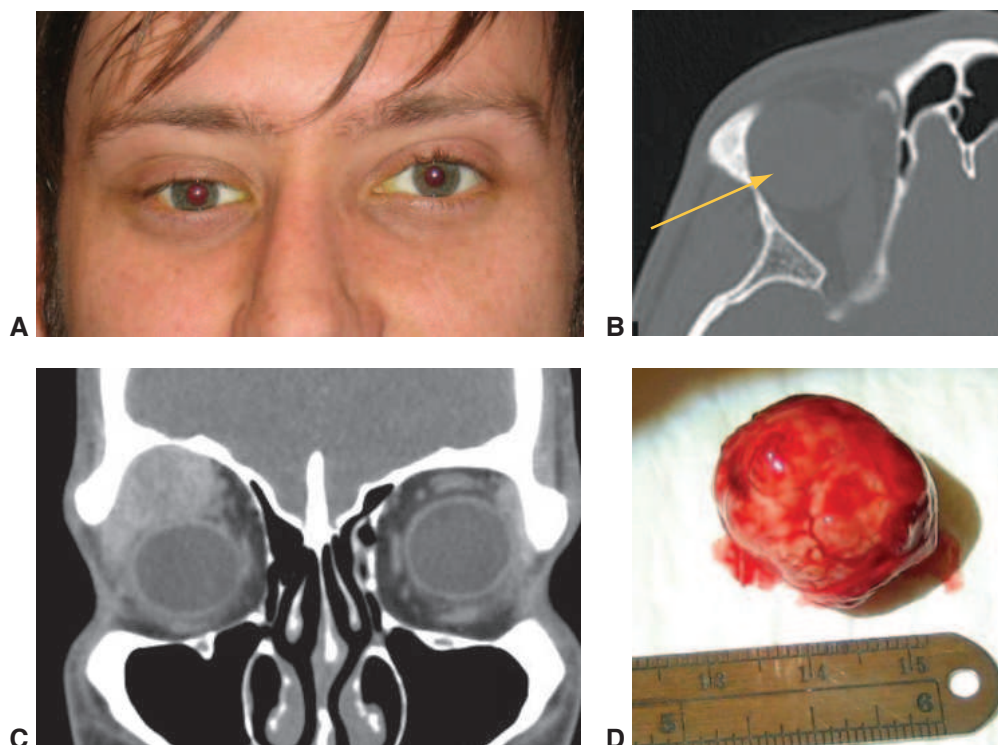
Pleomorphic adenoma. A, Adult male with inferomedial displacement of the right globe. B, Axial CT scan shows a well-circumscribed mass (*arrow*) in the superotemporal orbit with no lytic erosion of the bone. C, Coronal CT shows the mass displacing the right globe inferiorly and medially. D, The mass was completely removed with the pseudocapsule intact through a lateral orbitotomy approach. (Courtesy of Eric A. Steele, MD.)
